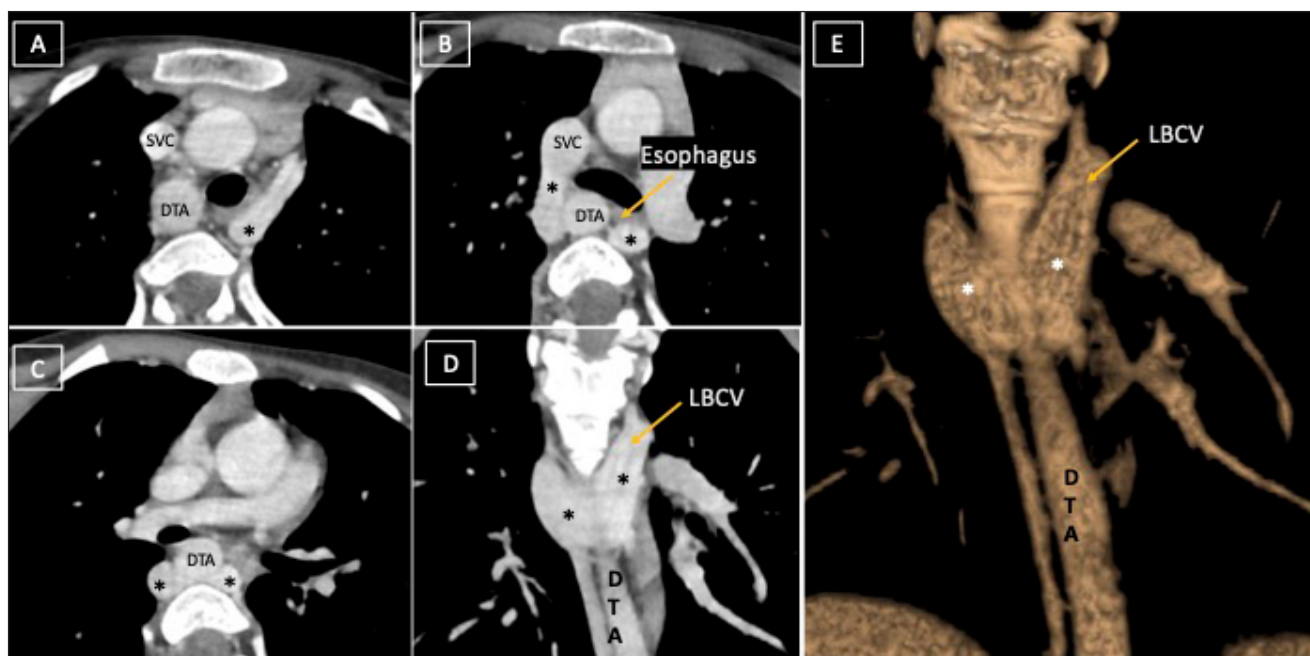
(A-C) Computed tomography angiography axial and (D) coronal image depicts retroesophageal U-shaped course of left brachiocephalic vein (LBCV, marked by *), which is joining the SVC. (E) Volume-rendered image depicts the anomalous course of LBCV. DTA: descending thoracic aorta; SVC: superior vena cava
